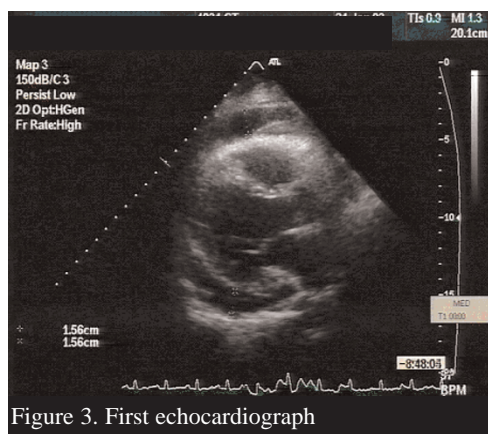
First echocardiograph
